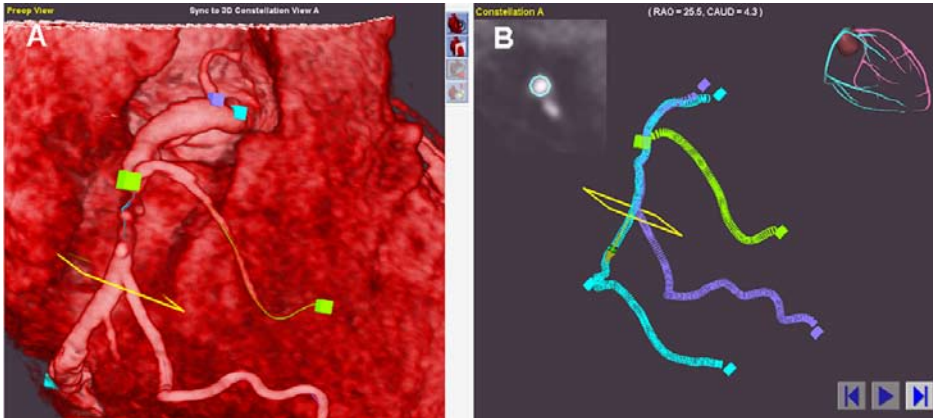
Using the Navigant® system the multislice CT data set can be used to create: (A) a road map of a chronic total occlusion not seen angiographically and (B) cross-sections along the map.
